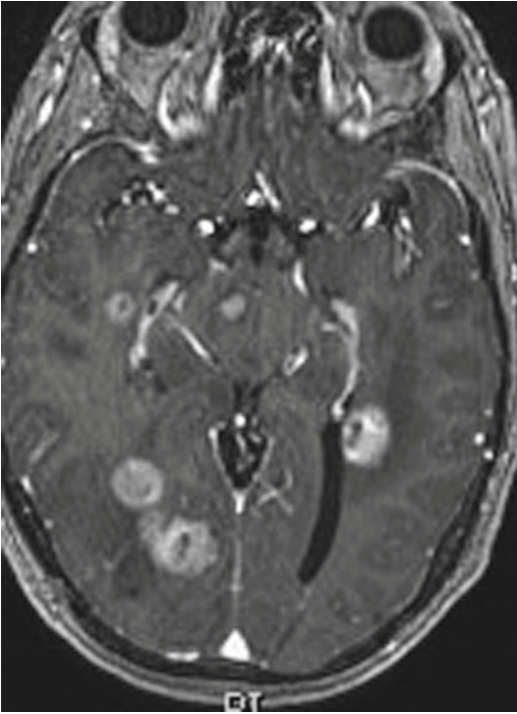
Cerebral metastases. Axial gadolinium-enhanced T1-weighted image reveals multiple enhancing brain lesions with surrounding low signal vasogenic edema in the cerebrum and pons
